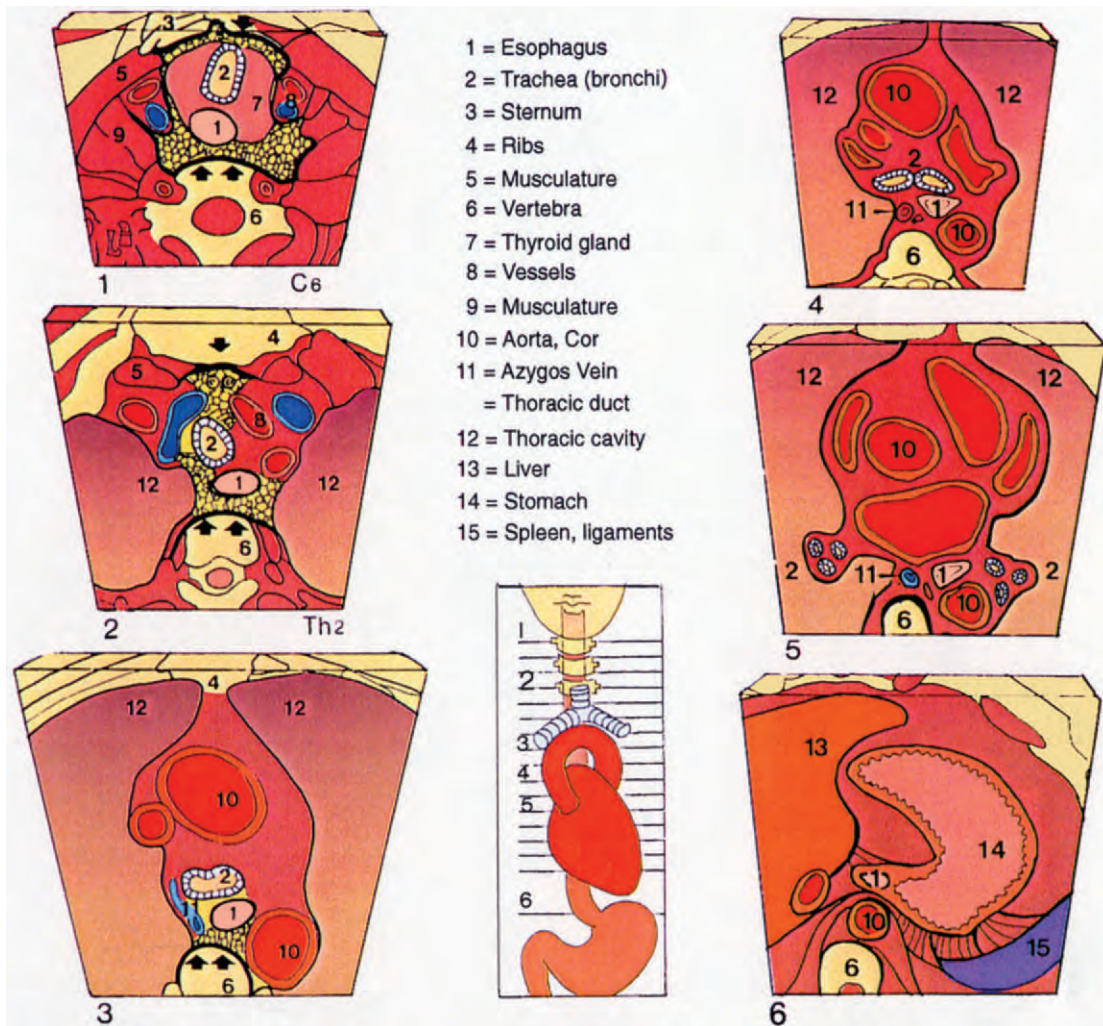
Topographic anatomy of the esophagus shown from the cervical level (1) to the esophagogastric junction (6). A transverse section through the mediastinum shows the esophagus and its surrounding structures in a computed tomographic aspect. The close positional relationship among the esophagus, trachea, and vertebrae and the fascial planes is displayed. The *thick dark lines* are the prevertebral and prevertebral fascia (*arrows*); the net-like pattern represents the respective areolar connective tissue. (Modified after Wegener OH: Neuromuscular organization of esophageal and pharyngeal motility. Arch Intern Med 136:524, 1976, with permission.)
